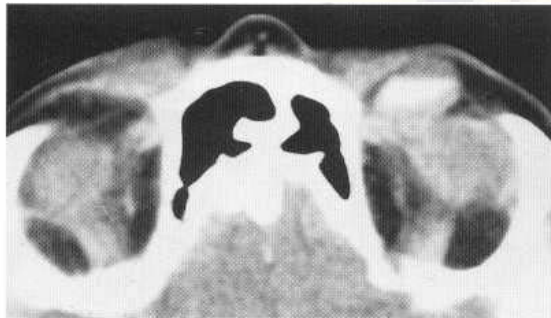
Varix. Contrast-enhanced CT demonstrates fluid-level within preseptal varix of left orbit.
